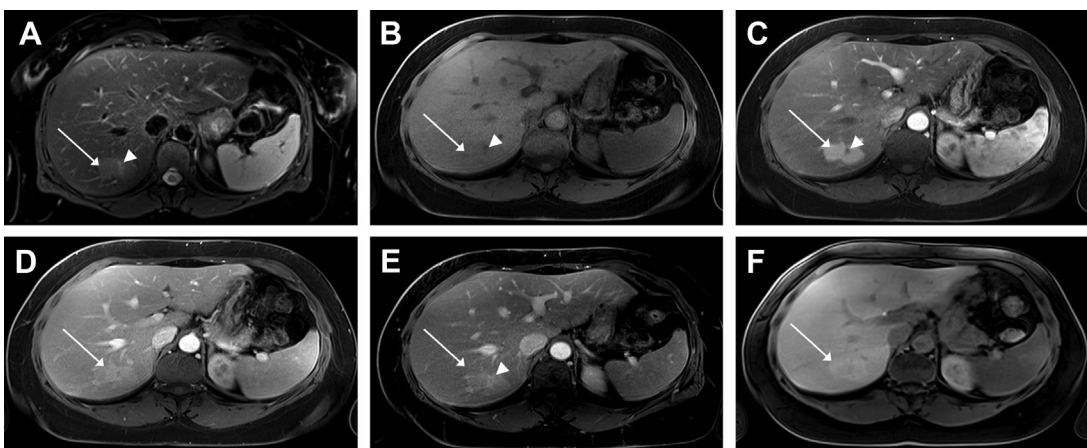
Typical MRI features of FNH. Lobulated lesion, slightly hyperintense on T2-weighted fat-saturated image (A) and isointense on T1-weighted fat-saturated image (B). After injection of gadobenate dimeglumine (0.1 mL/kg), the lesion shows homogeneous arterial phase hyperenhancement (C) without washout in the portal venous phase (D) or delayed phase (E). There is a central element (arrowhead) that is hyperintense on T2-weighted fat-saturated image and hypointense on T2-weighted fat-saturated image with delayed hyperenhancement. In the hepatobiliary phase (F), the lesion demonstrates homogeneous hyperintensity consistent with increased uptake of the contrast agent, promoted by increased OATP expression on a molecular basis.
